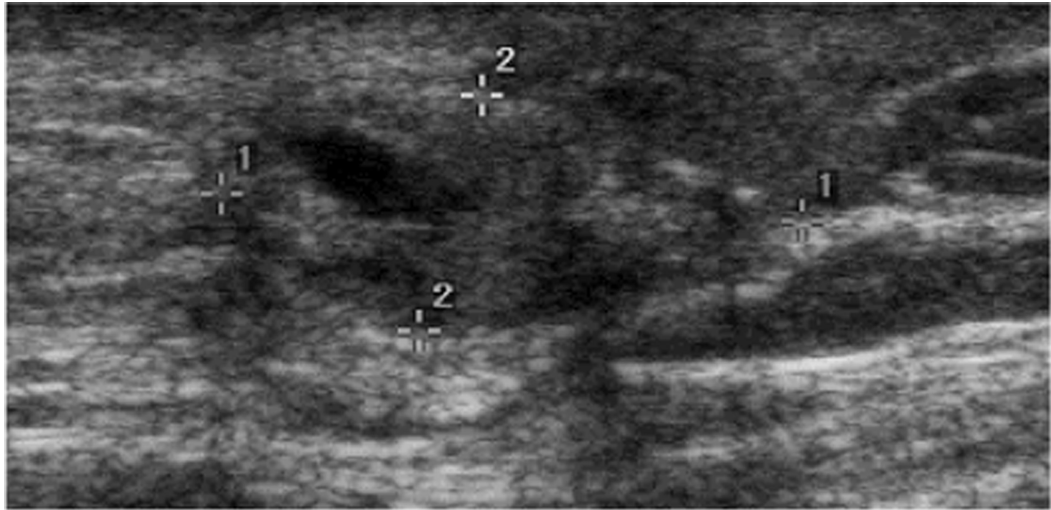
Patient status post-mastectomy with TRAM flap reconstruction and a palpable mass in the reconstructed left breast. On ultrasound (fig. 5a) it appeared as an oval parallel isoechoic mass with central anechoic component (arrow). Cone mammographic (fig. 5b) view over the palpable mass shows an area of increased density and central fat (arrow) consistent with fat necrosis.
